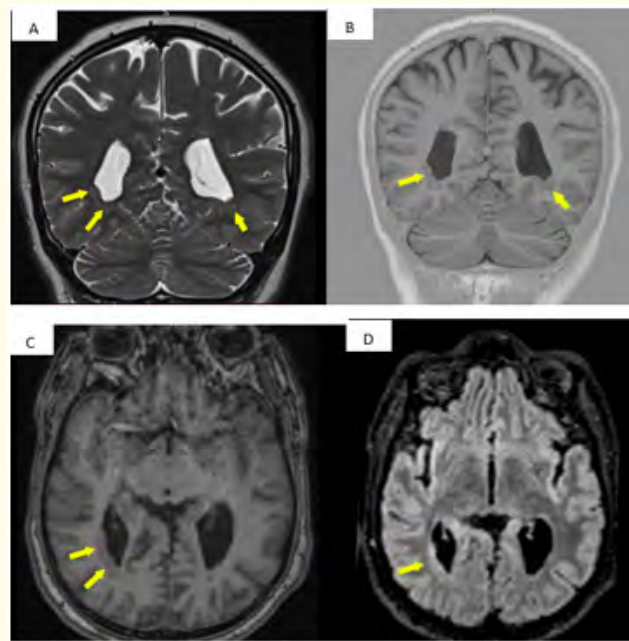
Brain MRI in coronal T2 (A), coronal T1R (B), axial T1 (C) and axial flair (D) shows the presence of nodular lesions (large yellow arrows) in the occipital periventricular area with a similar signal to that of the grey matter.
